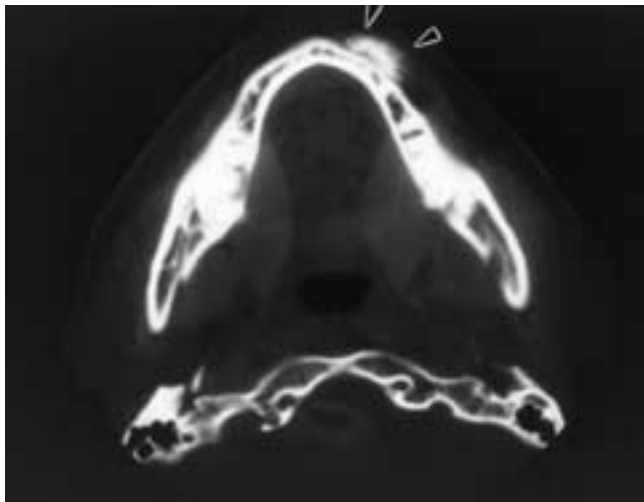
Osteogenic sarcoma in the anterior part of the mandible. Axial CT demonstrates a mass with periosteal reaction suggesting the typical “sun-ray” appearance in the mandible (arrowheads).
